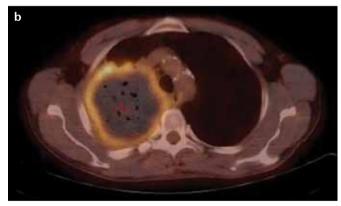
a, b. Transaxial FDG PET image (a) and FDG PET-CT fusion image (b) depict the high uptake in the rim of the mass without any uptake in the center.
